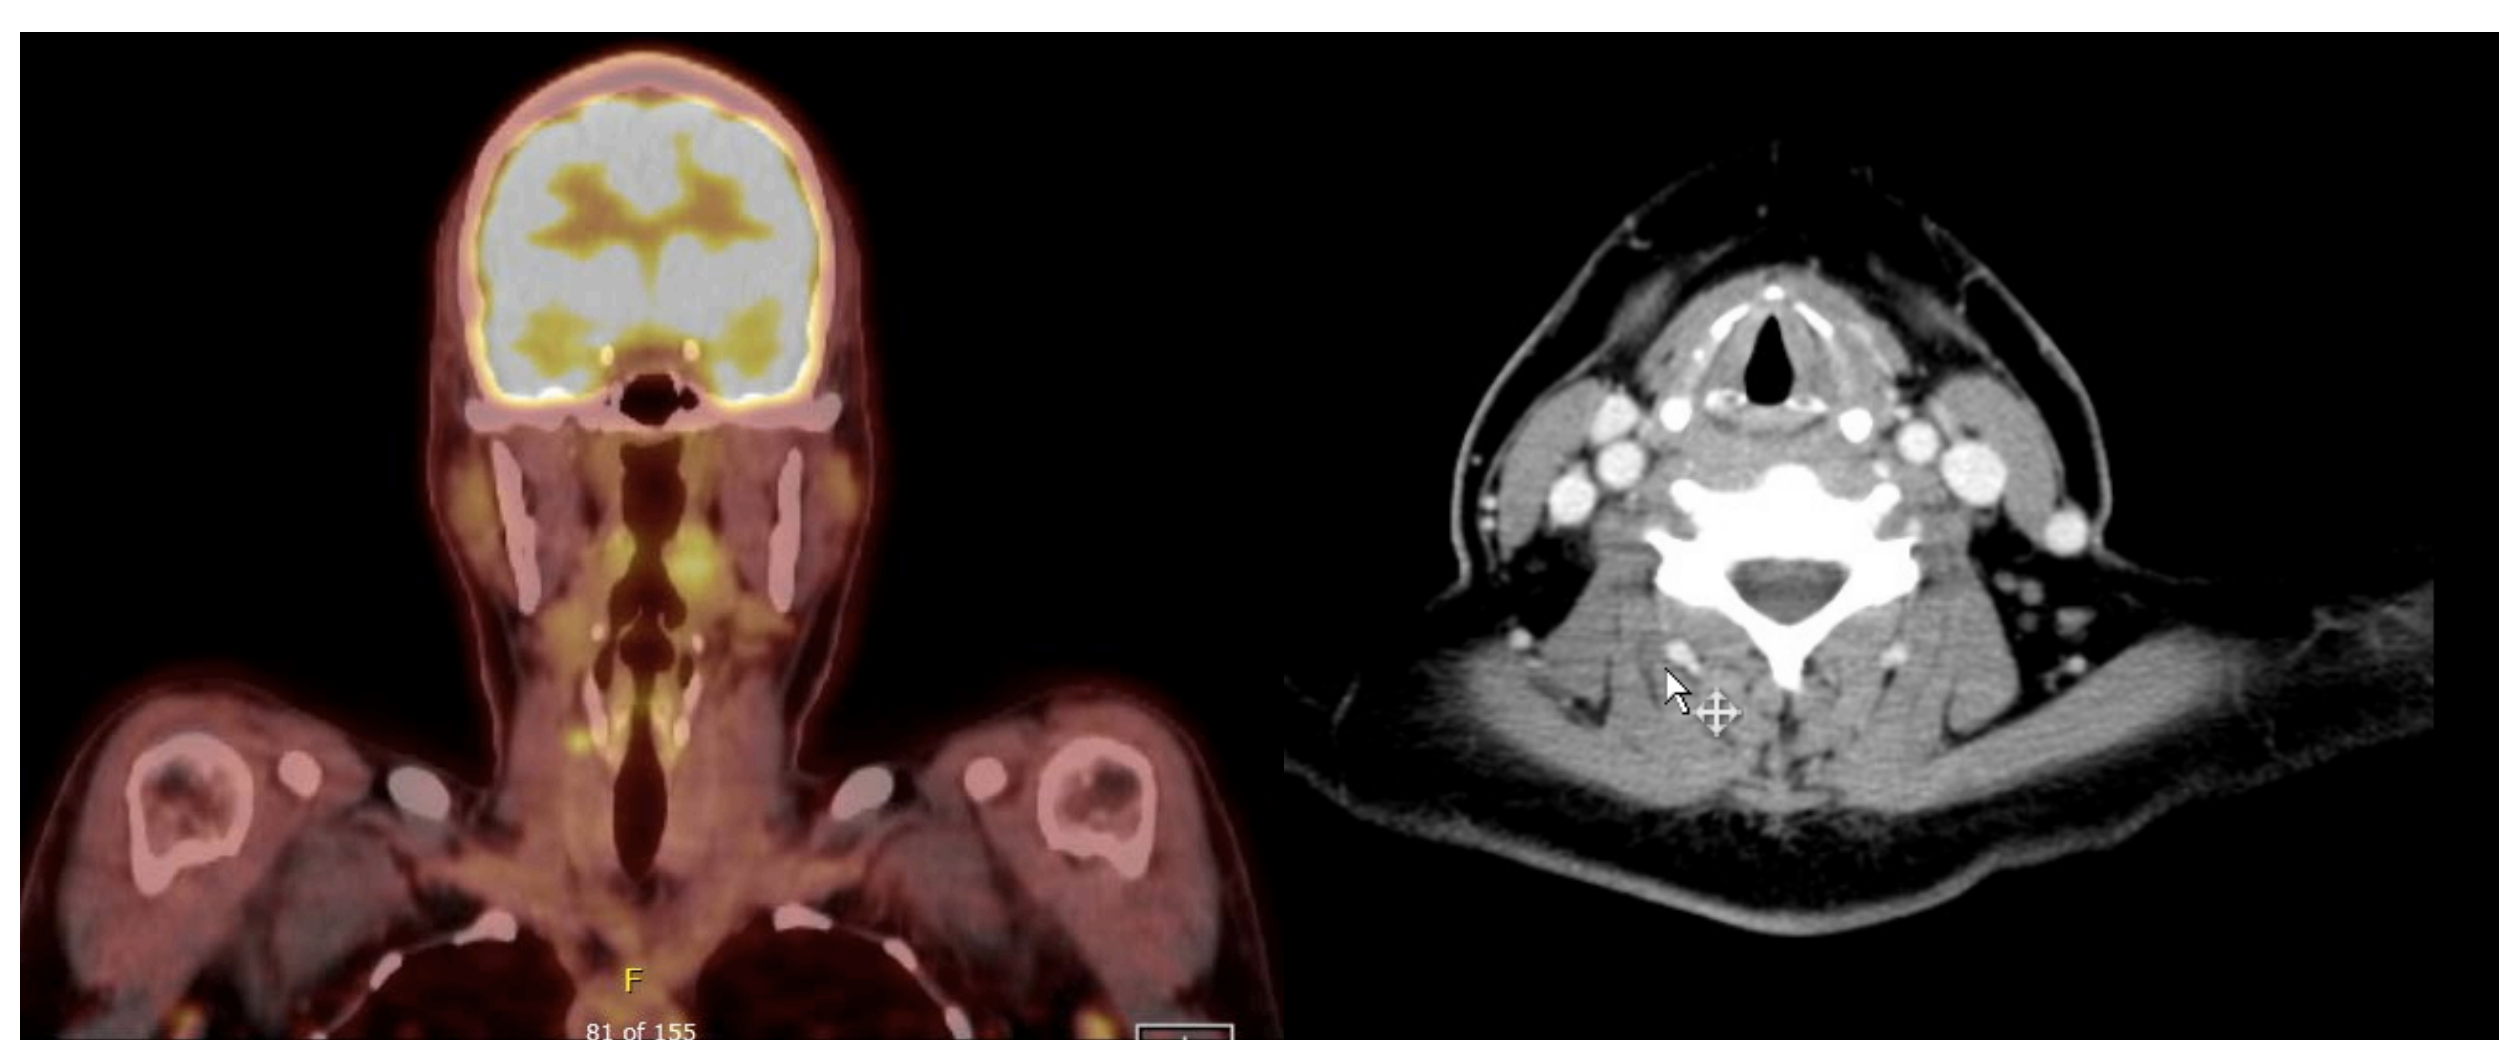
Immediate post-operative PET scan (left) and axial CT with contrast (right).
